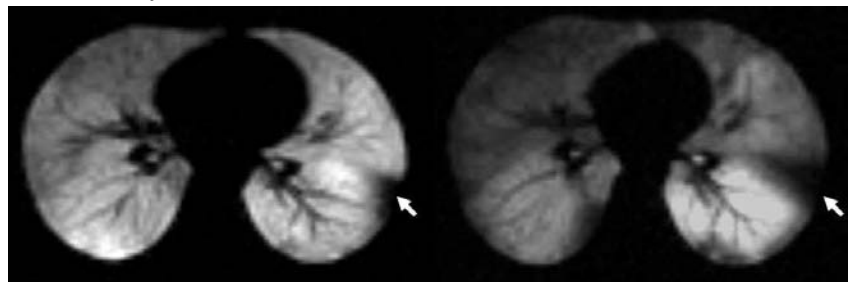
Axial H^3He MR images obtained 30 days apart demonstrate a persistent or recurrent left lower lobe ventilation defect.
